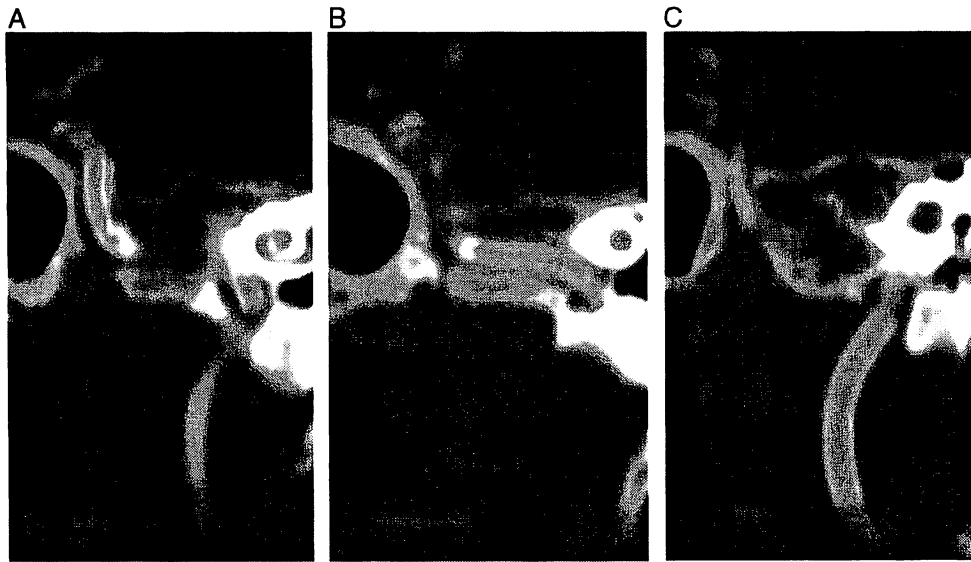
Follow-up computed tomography angiography (reformatted images) performed 4 months after the intervention, showing good patency of the stents and left carotid blood flow. A: The distal first stent. B: The second stent. C: The proximal third stent.
